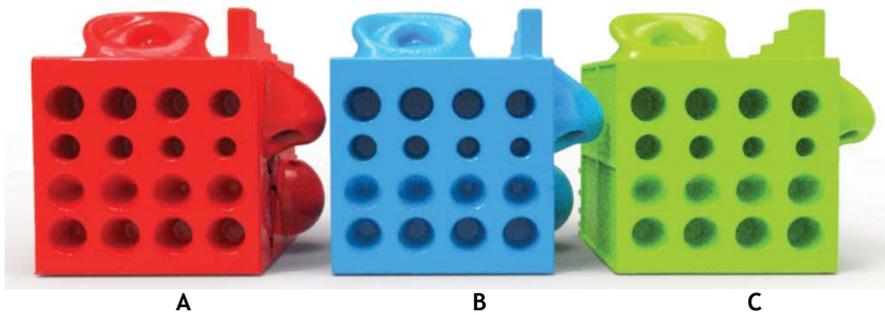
CT Results of Depth Test Features for 3D Doctor® (A), Mimics® (B) and Invesalius® (C).
